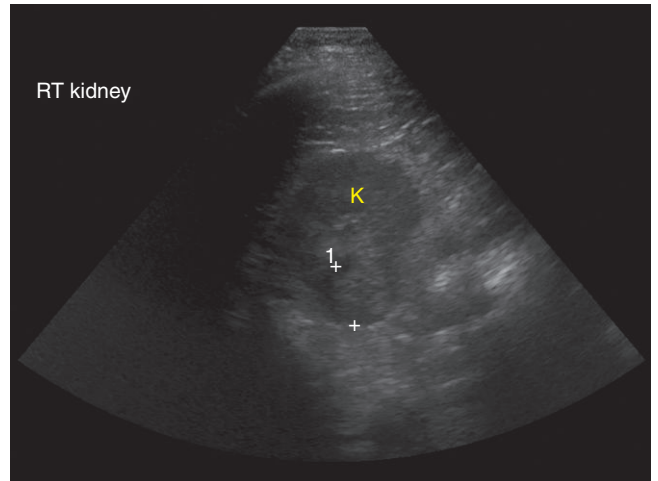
Ultrasound of the lower pole of the right kidney (K) demonstrating subtle 2.3-cm mass, outlined by calipers.
